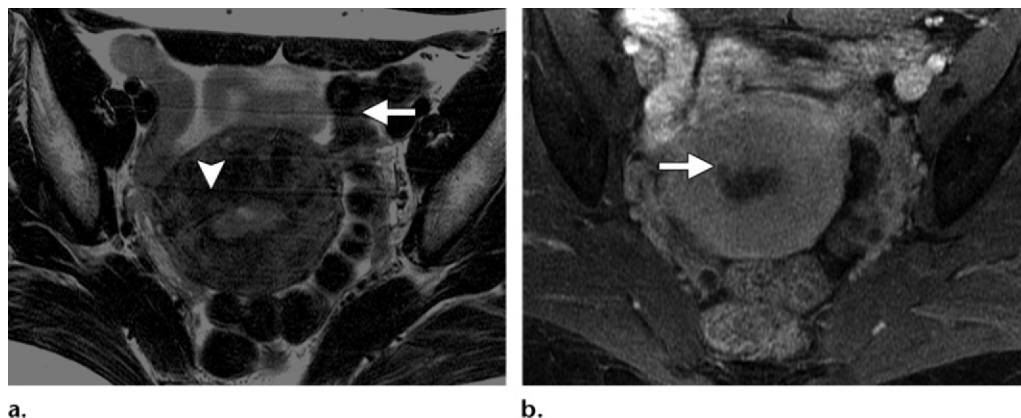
Coregistration of high-resolution T2-weighted FRFSE and dynamic contrast-enhanced MR imaging with the same section positions. (a) Axial high-resolution T2-weighted MR image obtained at the level of the uterus shows a hyperintense tumor in the endometrial cavity with a subtle signal abnormality in the anterior myometrium (arrowhead), a finding that may indicate invasion. Motion artifact (arrow) is also present, which limits evaluation. Note that an anterior saturation pulse was not placed over the anterior abdominal wall fat. (b) Axial contrast-enhanced T1-weighted 3D MR image obtained in the delayed phase shows invasion into the inner myometrium (arrow). Often, contrast-enhanced images obtained in the same plane as T2-weighted images confirm a subtle finding and provide a backup if one series is degraded by artifacts and is suboptimal for diagnostic evaluation.
